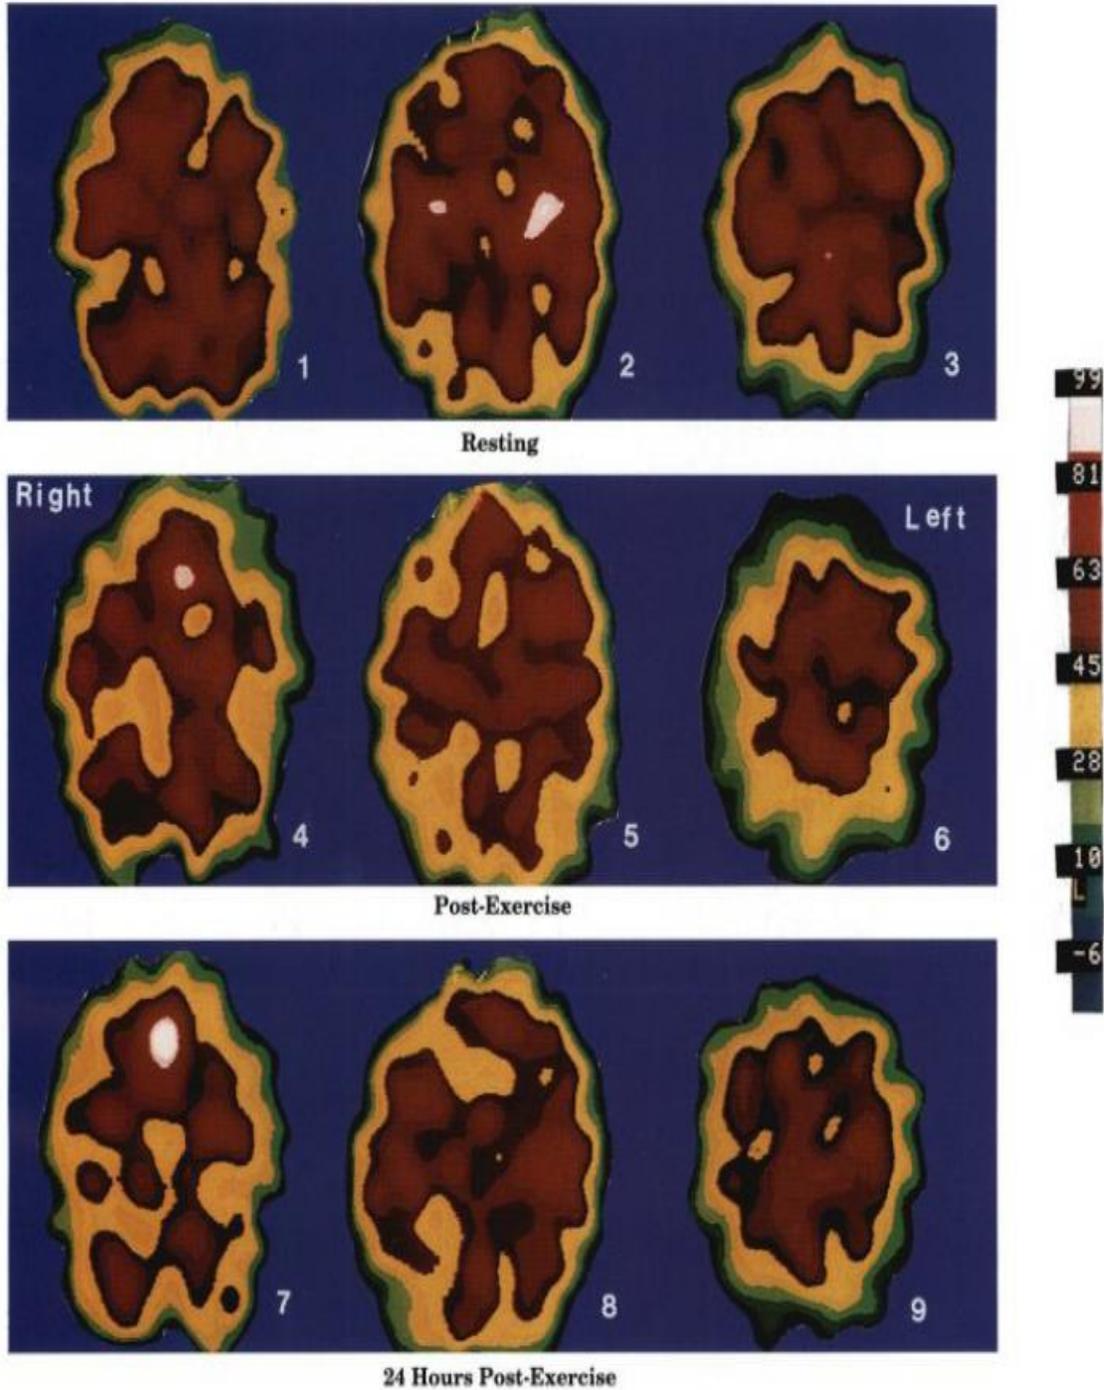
Already low blood supply in the ME/CFS brain are worsened with exercise shown on SPECT; right and left hemispheres are here represented in reverse. (Hyde et al, 1992). Note the hypoperfusions at lateral boundaries represented by green through black on the color scale.
